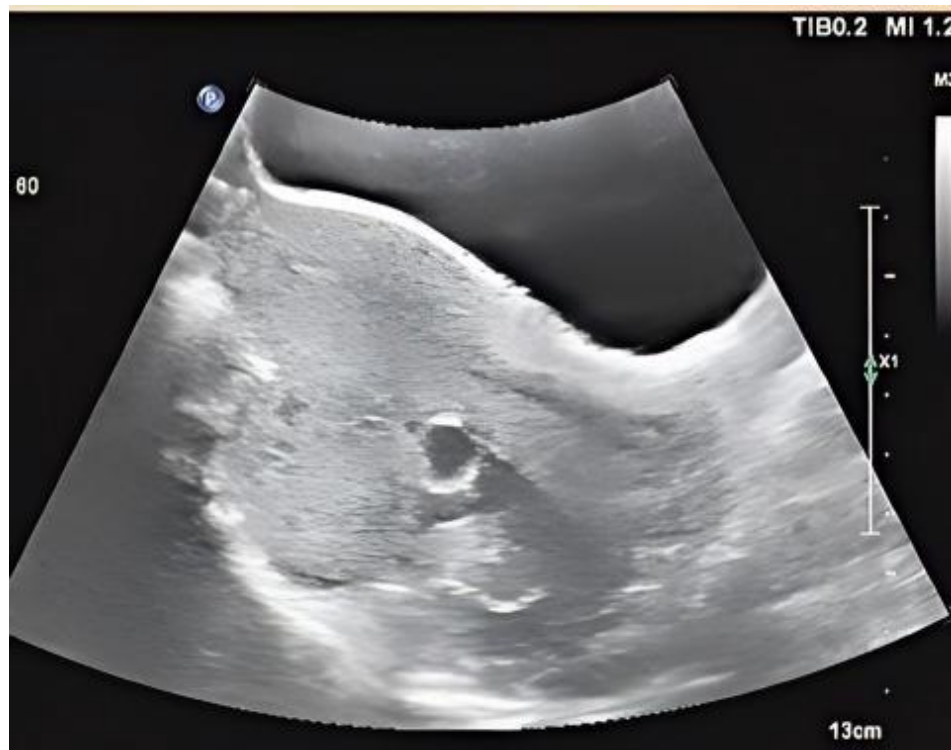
Pelvic ultrasound image. a ovary cyst, measuring 6 cm in diameter.
